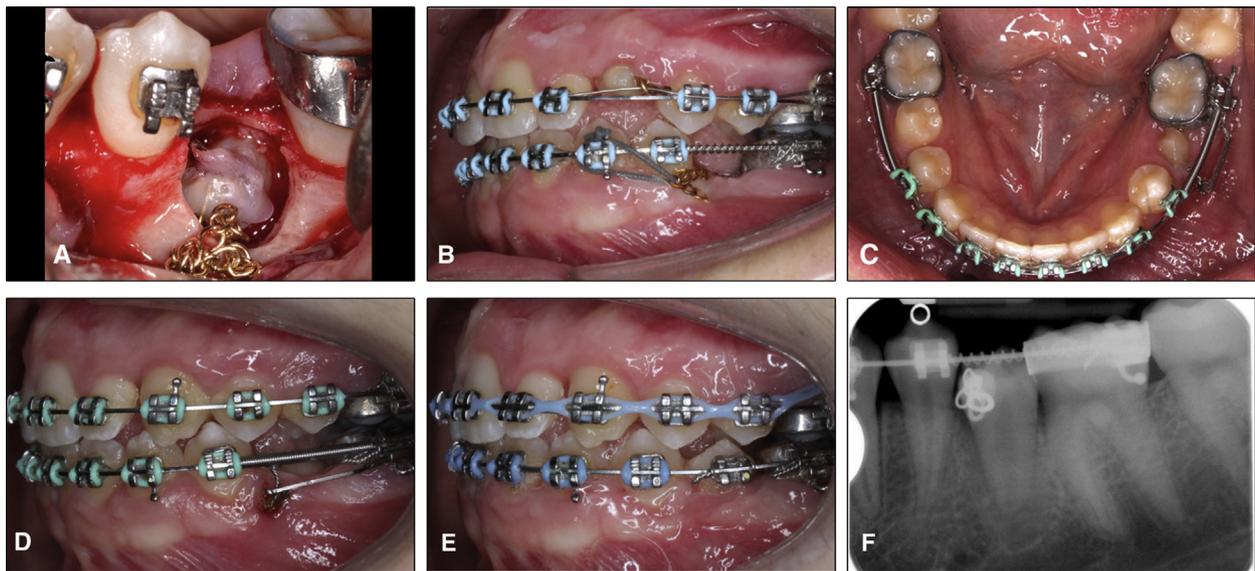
Progress intraoral photographs: orthodontic traction of the lower left second premolar and follow-up radiograph.
